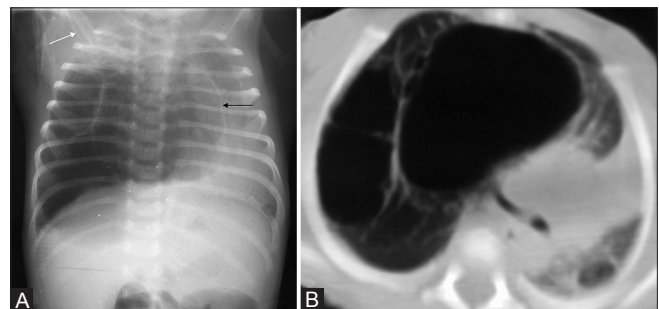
(A, B): Infant with respiratory distress. (A) Chest radiograph shows a multiseptated cystic lucency (black arrow) in the right lung field with mediastinal shift. A chest tube (white arrow) was inserted after mistaking it for a pneumothorax. (B) CT chest axial section with lung window shows multiple thin-walled cysts in the right upper lobe. Diagnosis was confirmed after surgery as type 1 CCAM
